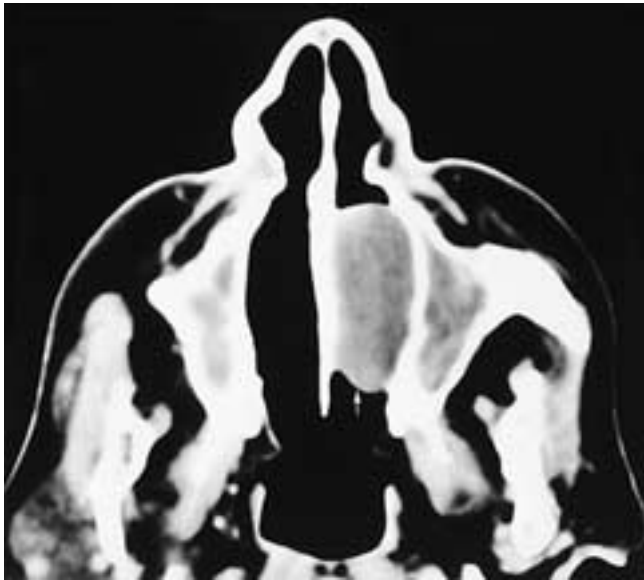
Axial CT scan shows a solitary mucoide attenuation left nasal mass (*arrow*). There are also secretions and inflammatory mucosal disease in both maxillary sinuses. This patient had a nasal polyp and sinusitis.
